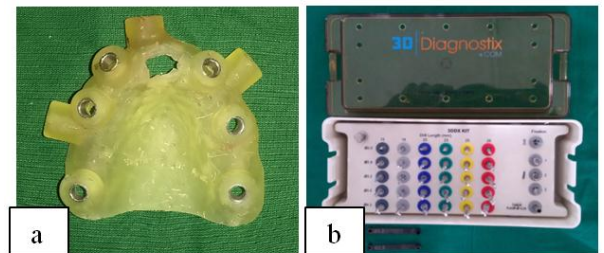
a) CBCT guided Stent b) surgical drill kit
